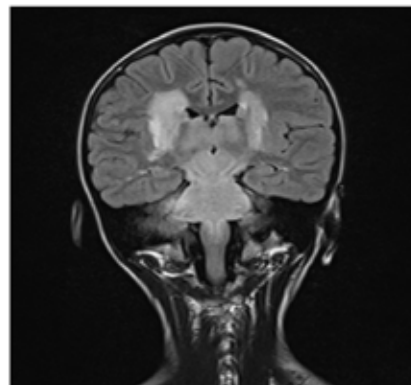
MRI cerebral showed contrast enhancement areas localized in medulla, pons, midbrain, thalamus, posterior lenticular nuclei, supranuclear white matter
